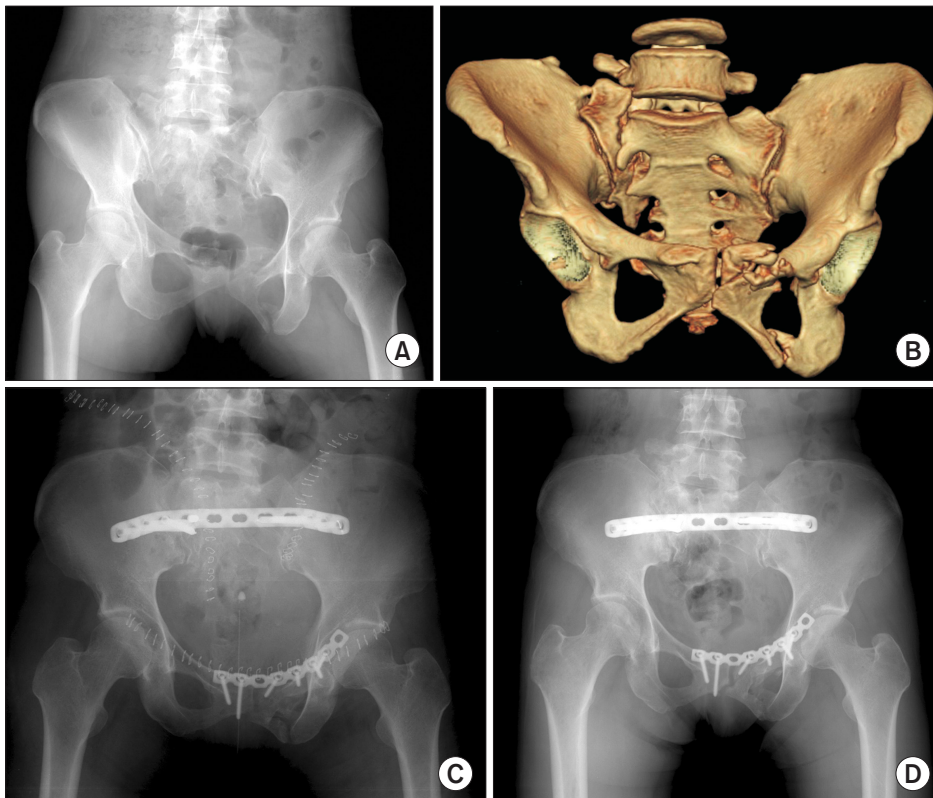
Case 4. (A) Initial anteroposterior radiograph. (B) The three-dimensional computed tomography image shows nonunion through the right sacrum and the left pubic rami, with displacement. (C) The postoperative anteroposterior view shows correction of the deformity. (D) The radiograph obtained 14 months after surgery shows a well-maintained reduction.
